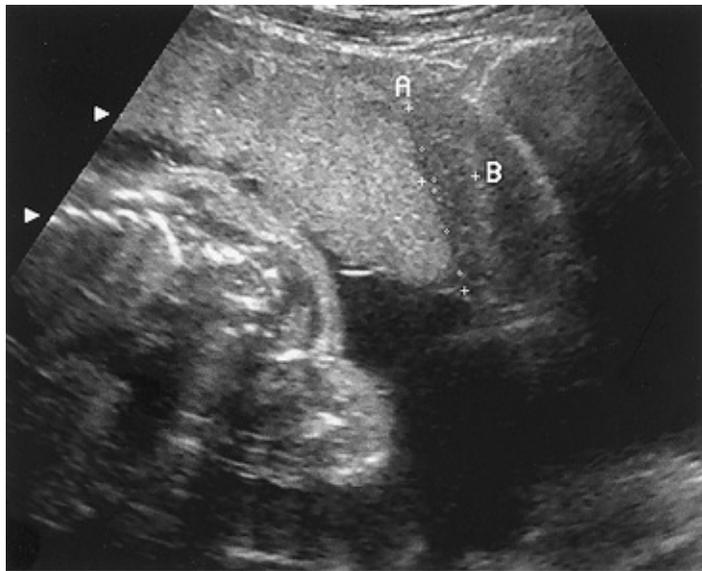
Transvaginal ultrasound image of a retroplacental abruption. The markers indicate the size of the clot, 3.5 × 1.0 cm.
